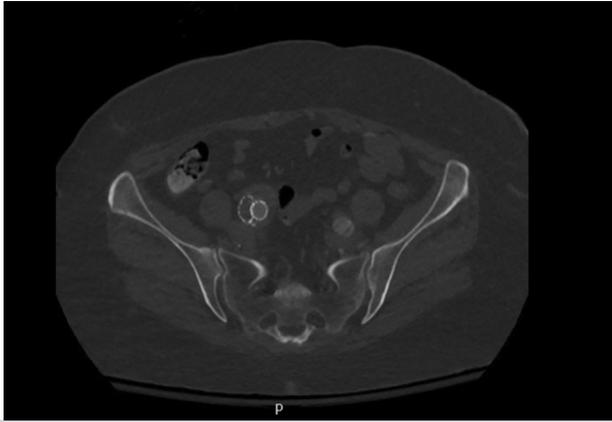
Computed tomography (CT) scan after fenestrated endovascular aortic repair showing an occluded right internal iliac stent.
